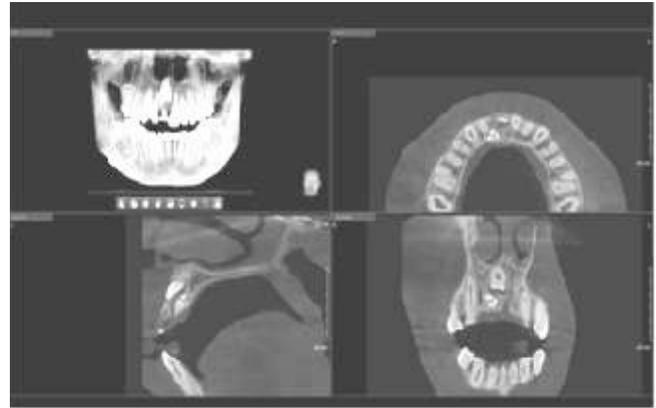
shows multiplanar reconstruction and coronal, sagittal and axial section in cbct
